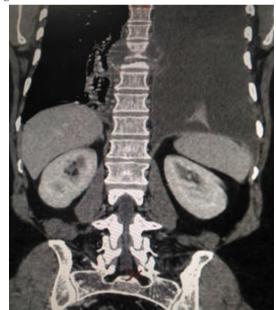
CT abdomen coronal section
